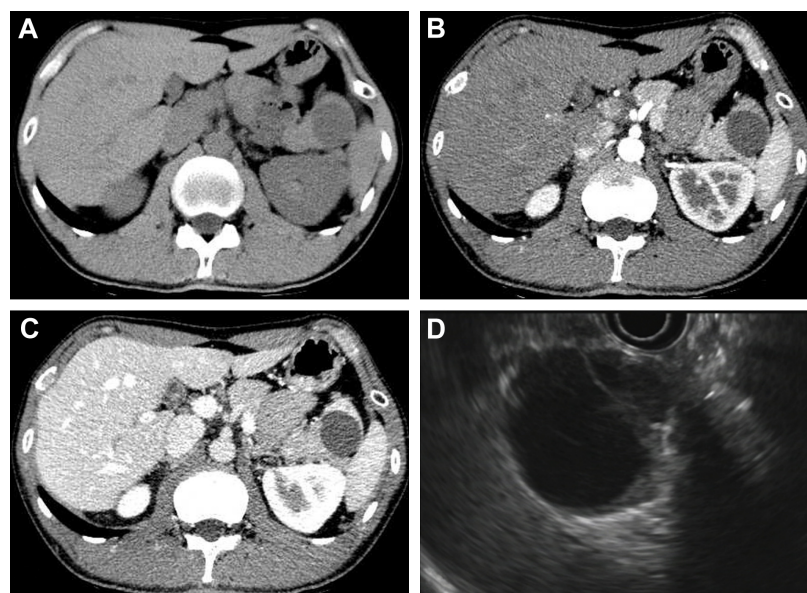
The abdominal computed tomography (CT) scan confirmed a well-defined cystic neoplasm in the pancreatic tail (A), without enhancement in the arterial phase (B) and the portal phase (C). Endoscopic ultrasonography (EUS) showed a 3.5 cm multilocular cystic lesion in the pancreatic tail with an internal nodule (D).
